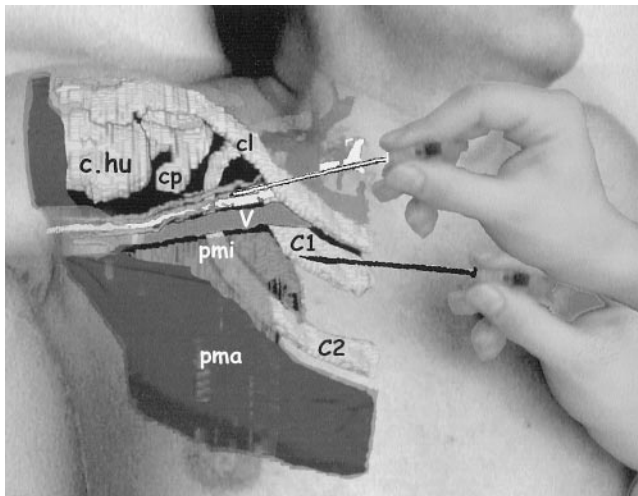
Front view of infraclavicular anatomy, right side, arm 90° abducted (Volunteer 1). Merging segmented magnetic resonance images with a correlated surface picture of the identical person created the picture. The hand-held white and black needles demonstrate point of needle insertion and needle direction by using the lateral approach for infraclavicular brachial plexus block and the infraclavicular brachial plexus block described by Raj et al. (1), respectively. The subclavian/axillary artery (white) is not marked, but is located cephalad to the corresponding vein (V). The cords (gray), not marked, surround the artery longitudinally. Only parts of the pectoralis major muscle (pma, dark) and the pectoralis minor muscle (pmi, gray) are presented, caudad to the axillary vein. cl = clavicle, C1 = first costa, C2 = second costa, cp = coracoid process, c.hu = caput humeri.
